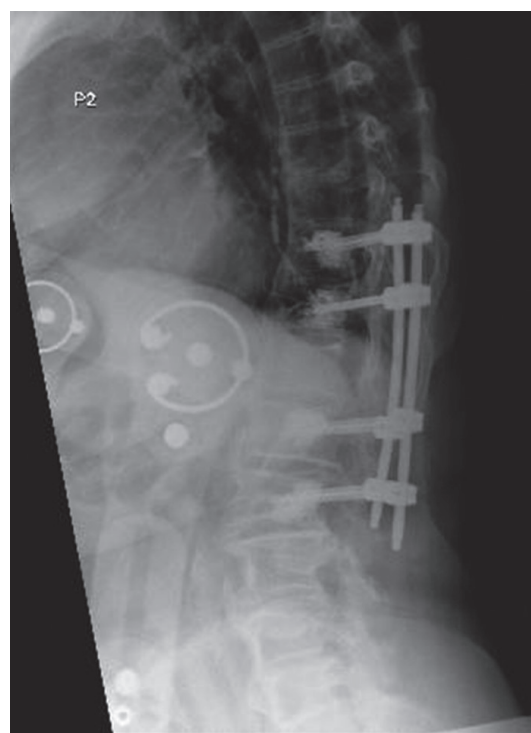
X-ray after surgery with 4 segments fixation.
